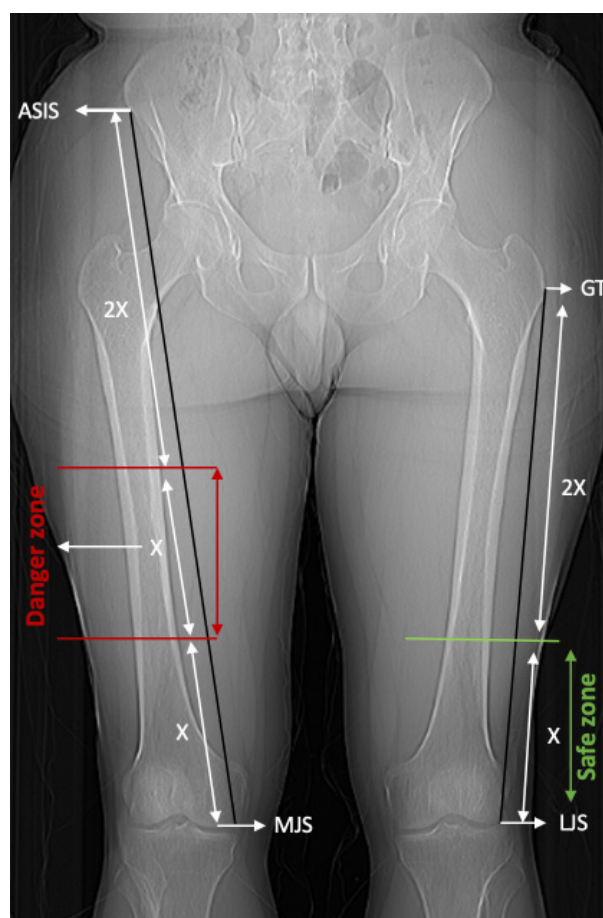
Maintenance of safe and danger zones in the CTA scanogram.
